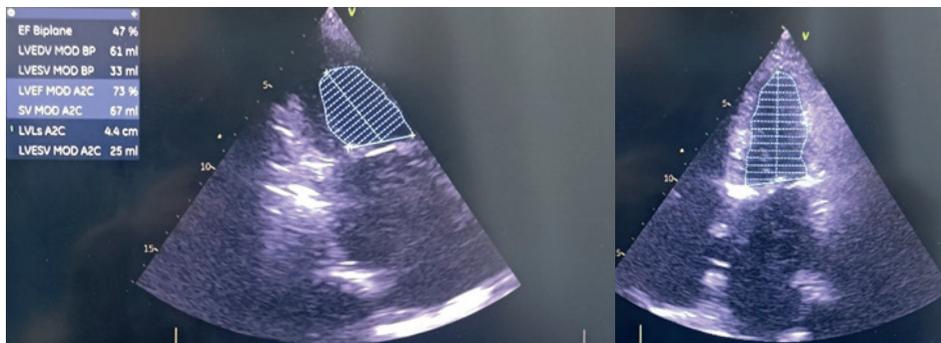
Assessment of left ventricular ejection fraction by Simpsons method in apical 2- chamber and 4- chamber views
